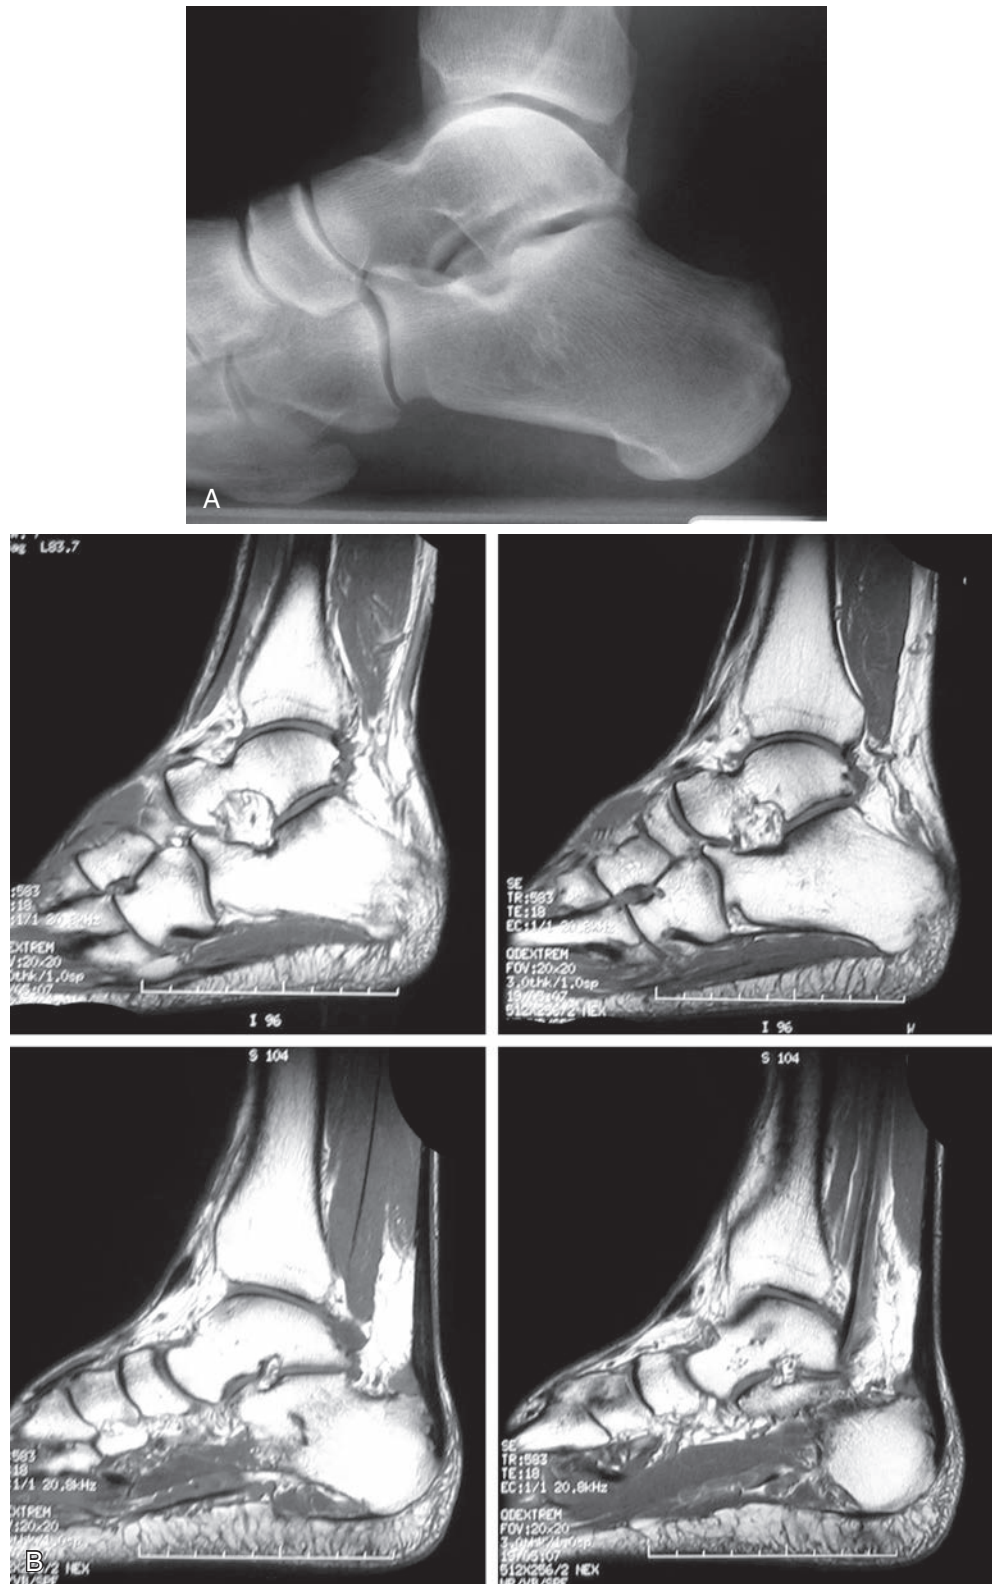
(A) through (C) This athlete's x-rays and sagittal magnetic resonance images demonstrate a Haglund deformity, retrocalcaneal bursitis, posterior calcaneal bony edema, and some insertional Achilles tendon changes. (D and E) Because all the tenderness and prominence were lateral and there was no tenderness as the Achilles insertion, a lateral approach was chosen, with the intraoperative option of an additional medial incision to contour the sides. (F) Bone resection should be performed just proximal to the insertion of the tendon. A power reciprocating rasp should be used to help contour all edges by the tendon. (G) A mini-C arm should be used to help identify any remaining prominences.
